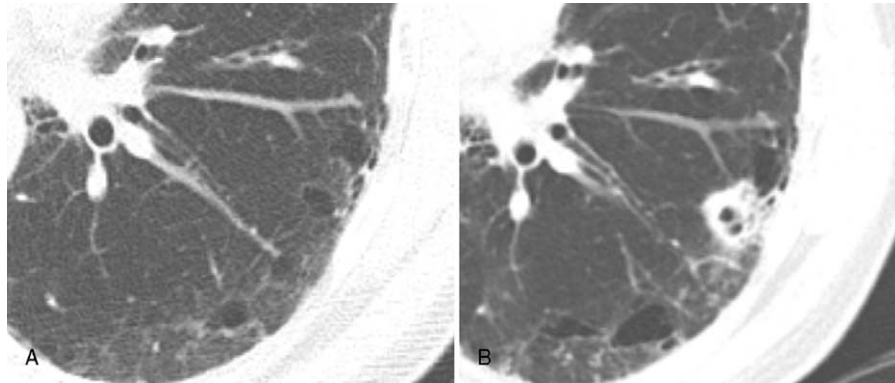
CT images showing 4 axial locations of lung cancer. The axial location of the main opacity, as seen in the transverse image, is evaluated as the association of the tumor-like lesion with fibrotic lung cysts; mixed-up area of honeycomb cysts, reticulation, traction bronchiectasis, and emphysema. The axial location is subcategorized as (A) at the interface of fibrotic cysts and a normal lung in Cancer-IIP, (B) in the midst of fibrotic cysts in NTM-IIP, (C) within ground-glass opacity in Cancer-IIP, or (D) confined in a normal lung in NTM-IIP. Cancer-IIP = newly detected lung cancer in an idiopathic interstitial pneumonia patient, NTP-IIP = newly detected pulmonary nontuberculous mycobacterial infection.
